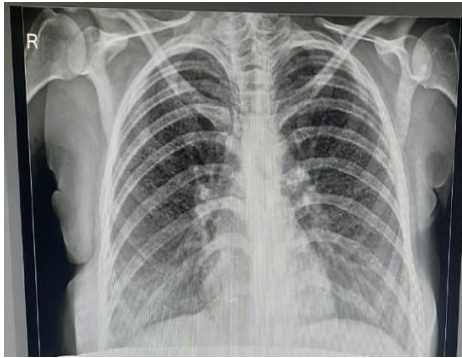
Patient 2. X-ray chest Posterior-Anterior (PA) view shows miliary deposits of 1-3mm diameter nodules, uniform in size and uniformly distributed.
